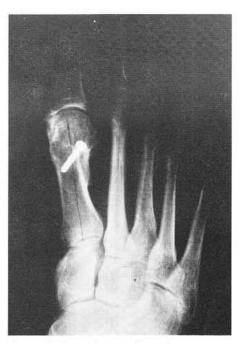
Dorsoplantar radiograph.
